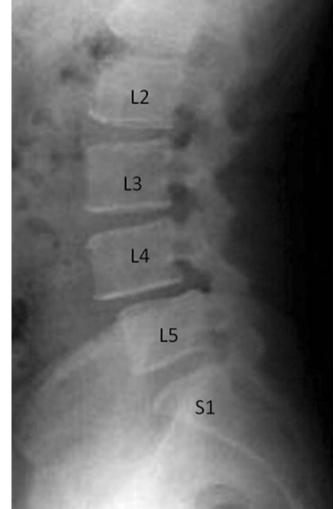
Lateral radiograph of the lumbar spine shows reduction of disc height at multiple levels, most prominently at L4–L5. Also pictured at L4–L5 is spondylolisthesis, where the L5 vertebral body is located posteriorly to the L4 vertebral body. (Reprinted by permission from Springer Nature: Surgical Indications for Lumbar Degenerative Disease by Ravi R. Patel, Jeffrey A. Rihn, Ravi K. Ponnoppan et al. Copyright 2014)
